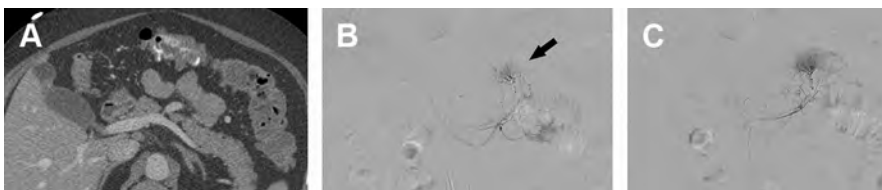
CTA and DSA of active GI bleed. A 58-year-old woman presents with dark red bowel movements and dizziness. Axial CT in portal venous phase (A) demonstrates contrast extravasation into the transverse colon. Superselective DSA of the middle colic artery in the early (B) and more delayed (C) phase demonstrates a persistent blush of contrast (*black arrow*). Patient was treated with coil embolization. Patient had known angiodysplasia on the colon diagnosed on previous colonoscopy.
